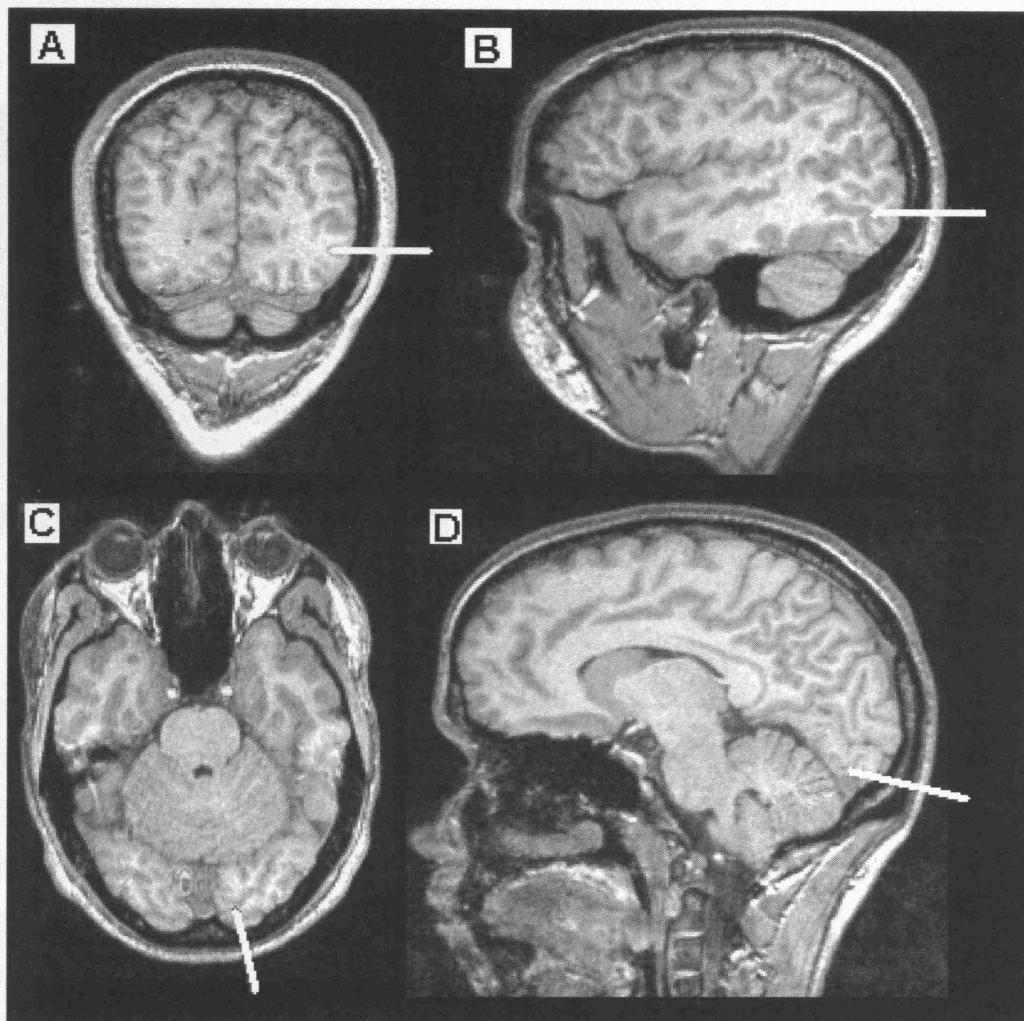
Coil locations of V5/MT (A: transverse view; B: sagittal view) and V1 (C: transverse view; D: sagittal view) stimulation on MRI image of one participant. The white lines represent the TMS trajectory. Note that left and right are reversed.
